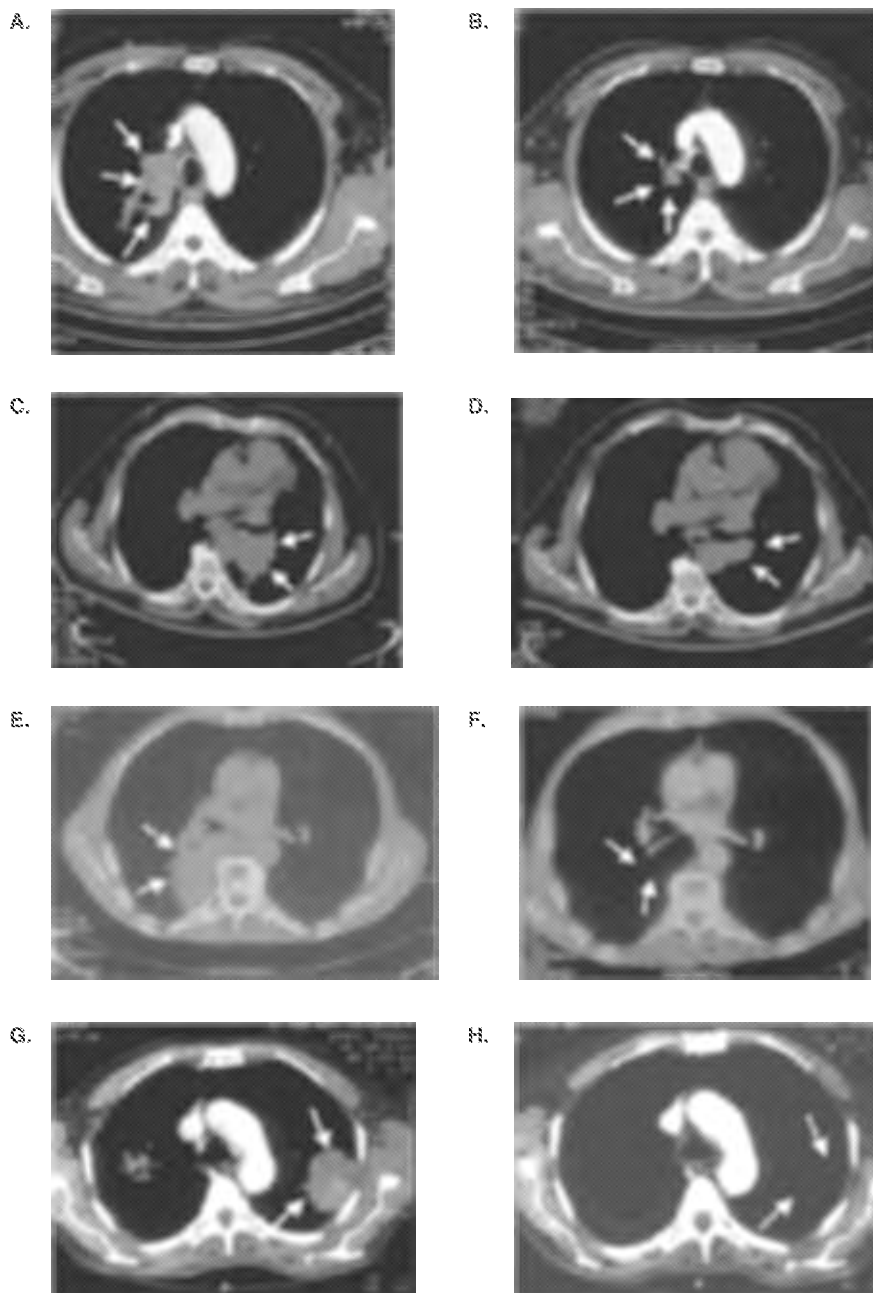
Patient cases from the Phase III study comparing Lipoplatin to cisplatin in combination with the same dose of paclitaxel documented with CT slices (with mediastinal window settings) before and after treatment. A. A low differentiated adenocarcinoma in the right upper lobe is present. B. The lesion was recorded as a partial response after four cycles of Lipoplatin–paclitaxel chemotherapy. C. A large adenocarcinoma cell tumor (arrows) in the left lower lobe. D. Follow-up scan taken after five cycles of Lipoplatin–paclitaxel treatment show reduction of volume of the lesion. E. CT section demonstrating a large tumor mass in the right lobe. F. Follow-up scan after nine cycles of Lipoplatin–paclitaxel treatment demonstrated a remarkable mass reduction. G. CT section demonstrating a large tumor mass in the left lobe. H. Follow-up scan after nine cycles of Lipoplatin–paclitaxel treatment showed mass reduction
